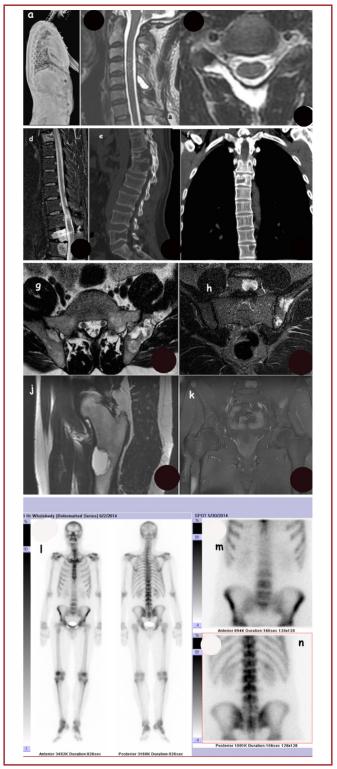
a) Preoperative lateral direct radiograph of the patient. Note the mild sagittal imbalance. b-c) Sagittal and axial MRI revealing the lesion in C5 vertebra. d-e-f) Sagittal MRI and CT reveal the lesions in T5 and T10, g-h-j-k) T12 and L1 and L5 vertebrae. Pelvic lesions demonstrated in axial and coronal MRI and right proximal femoral lesions demonstrated in sagittal and coronal MRI. l-m-n) The bone scan performed in the patient.
